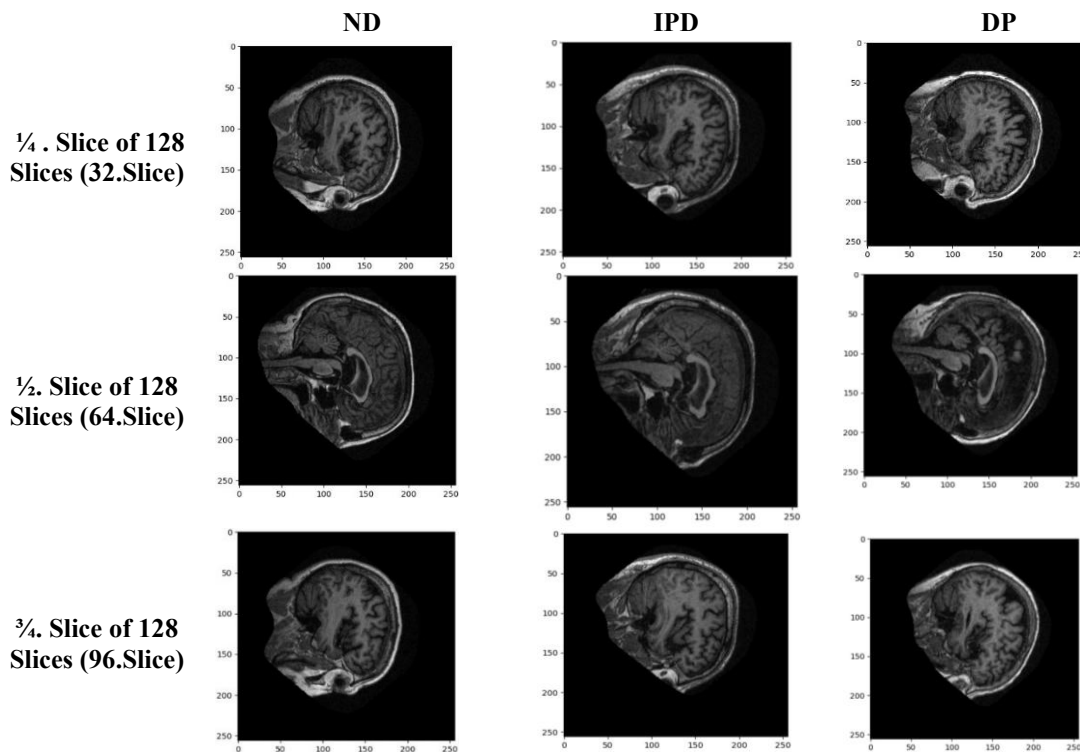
Slice Examples of MRI According to Classes from the Sagittal Plane
